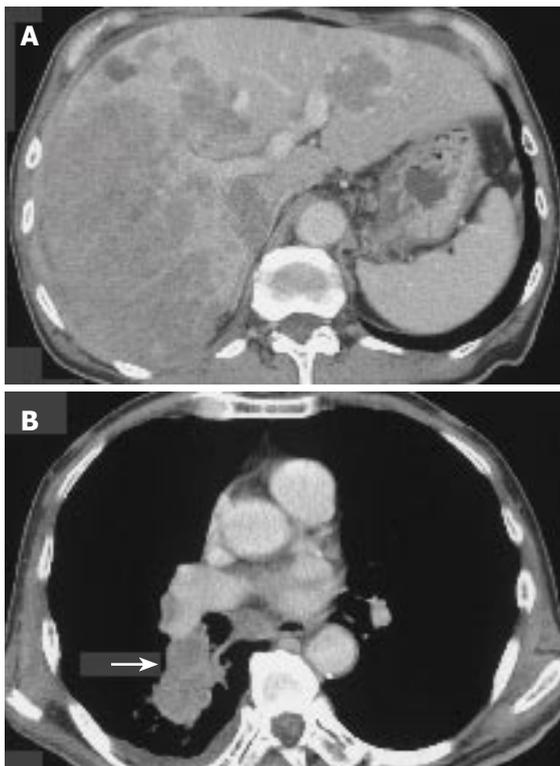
Computed tomography of the patient. A: CT of the abdomen showing multiple lesions and massively infiltrative process throughout the liver parenchyma; B: CT of the chest showing a right hilar mass (arrow) with pleural effusion.
